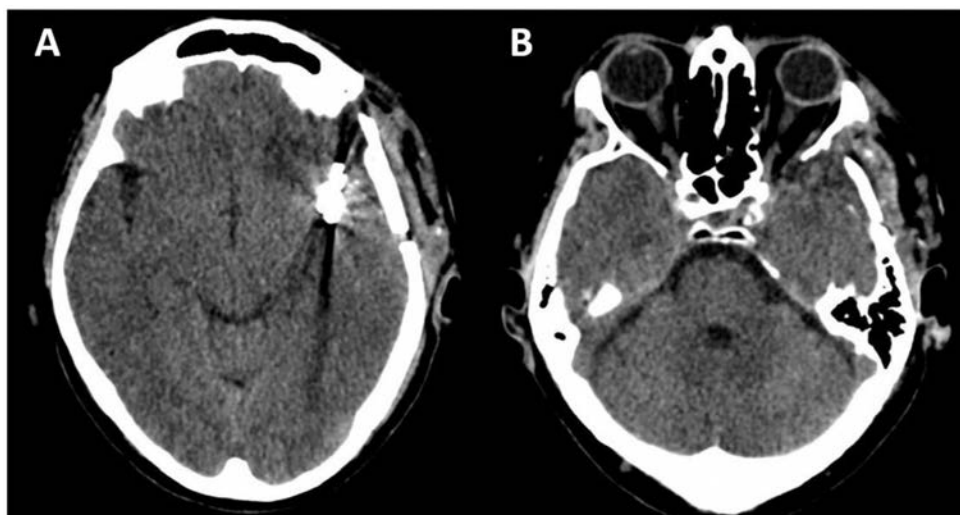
A. Postoperative imaging following microsurgical clip reconstruction. Axial postoperative computed tomography images demonstrate expected postoperative findings after clip reconstruction of the left middle cerebral artery aneurysm complex, with multiple clips visible in the left sylvian region. B. Follow-up imaging showed no evidence of recurrent hemorrhage, significant mass effect, or hydrocephalus progression.
